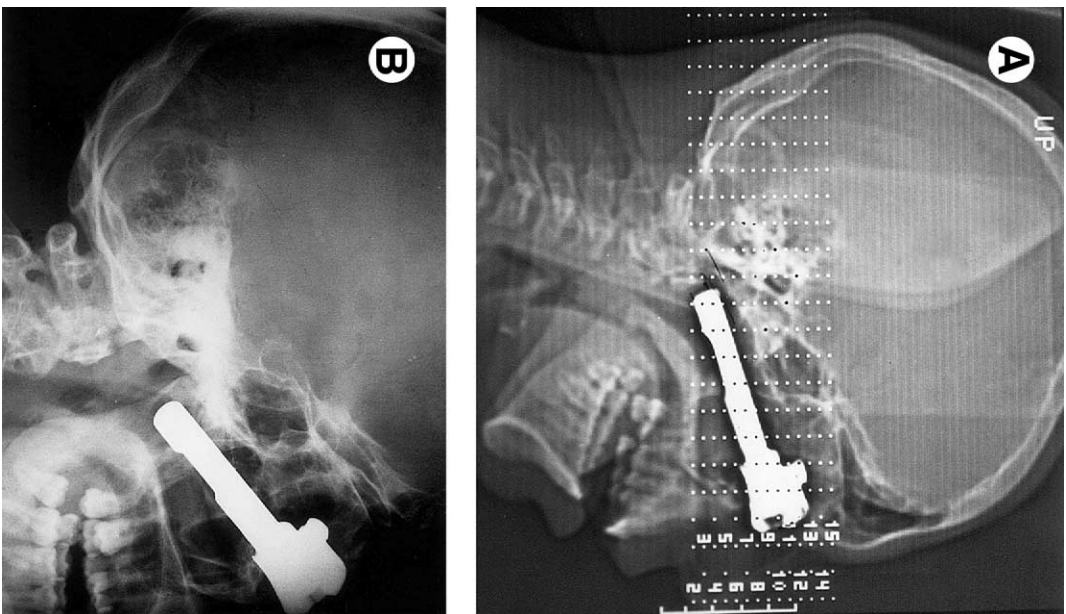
A, Computed tomography scan of a dislodged breech block impacted into the right orbit of a patient who fired a shot in the air when attempting to halt a vehicle. B, The object prevented mandibular opening.
